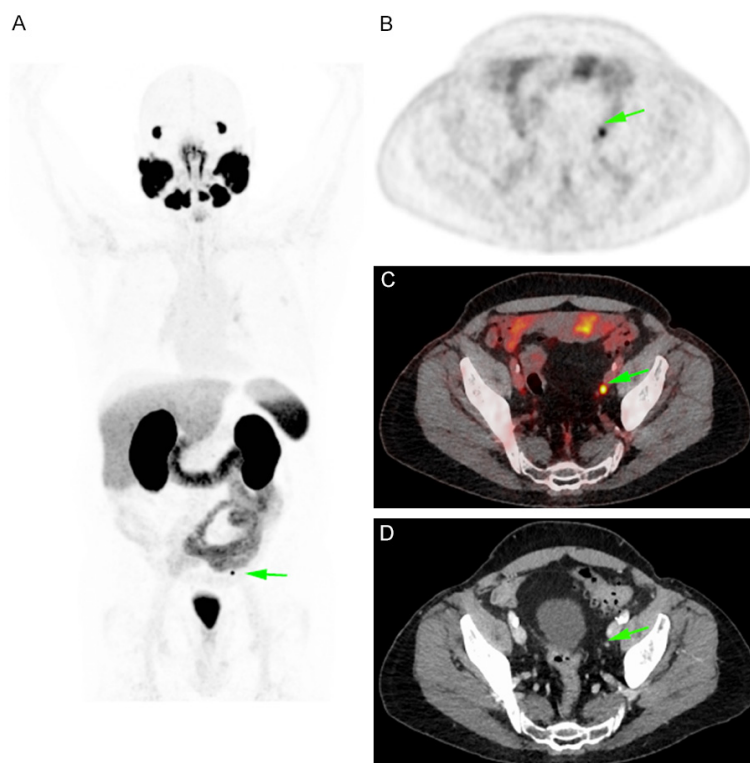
Restaging in a 74 years old patient in biochemical recurrence (PSA value: 0.2 ng/ml) showing only one lymph node measuring 4 mm and with a focal [⁶⁸Ga]Ga-PSMA-11 uptake (maximum Standardized Uptake Value measured at 15).
